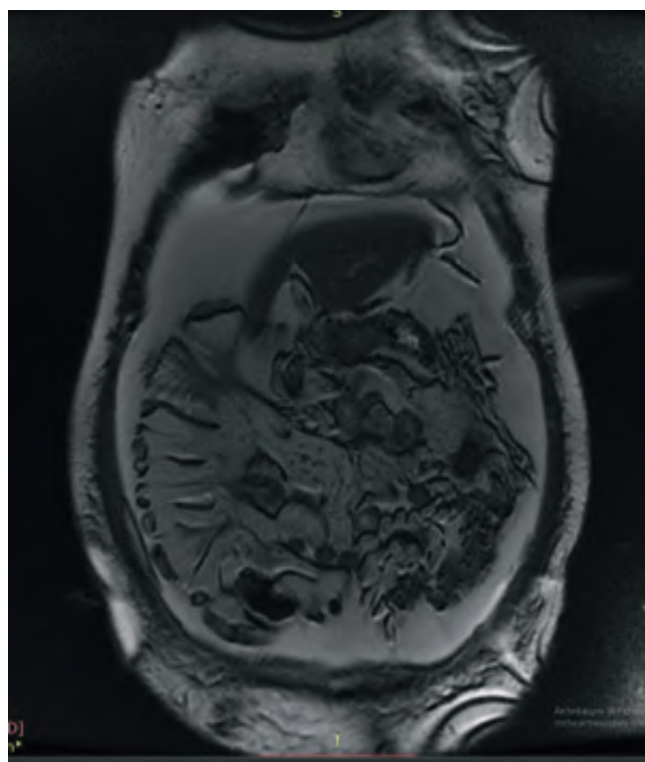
MRI of the abdomen and pelvic organs showing cystic masses in both ovaries with signs of peritoneal carcinomatosis.
